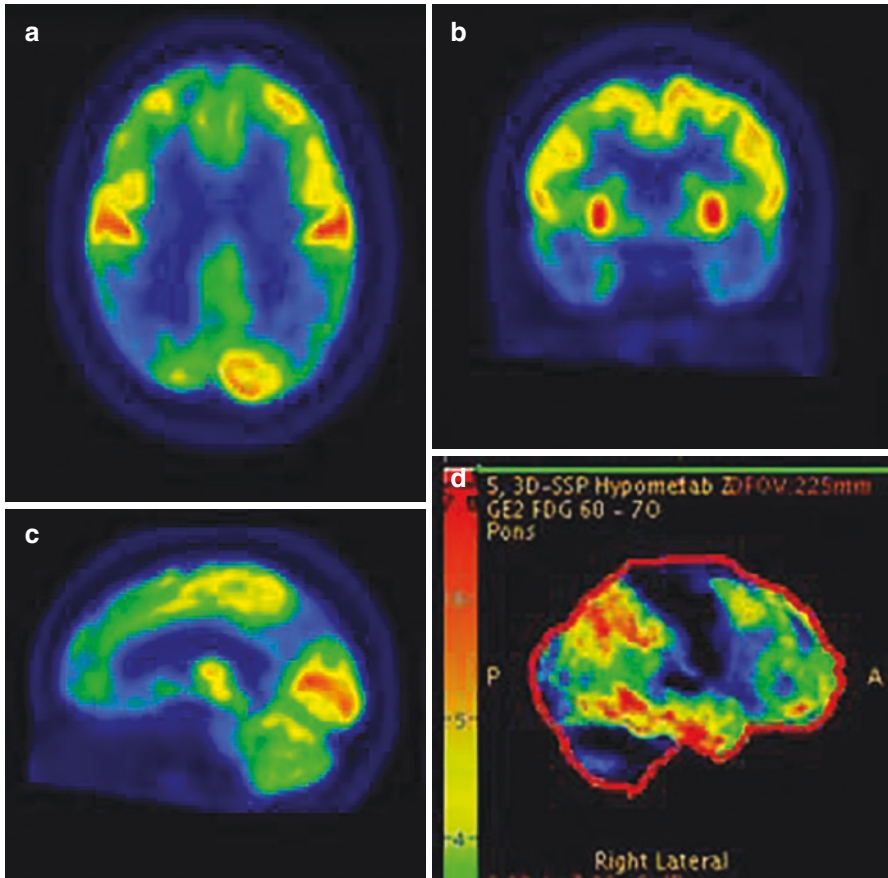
^{18}F -FDG brain PET/CT for dementia showing optimal display as well as 3D-SSP (stereotactic surface projections) with typical patterns of reduced uptake indicative of Alzheimer's disease. (a) Transaxial slice. (b) Coronal slice. (c) Sagittal slice. (d) 3D-SSP showing significant areas of reduced uptake (normalised to pons). Panel d demonstrates surface-rendered images of the statistical analysis. Showing a z-score map normalised using the pons with a threshold of $z > 2$
